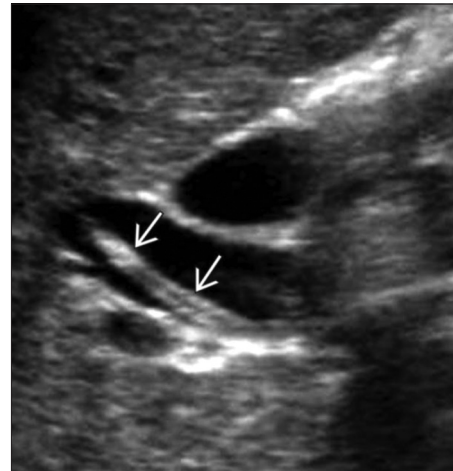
Ultrasonography showing double-linear echogenic structure suggestive of worm within dilated CBD
